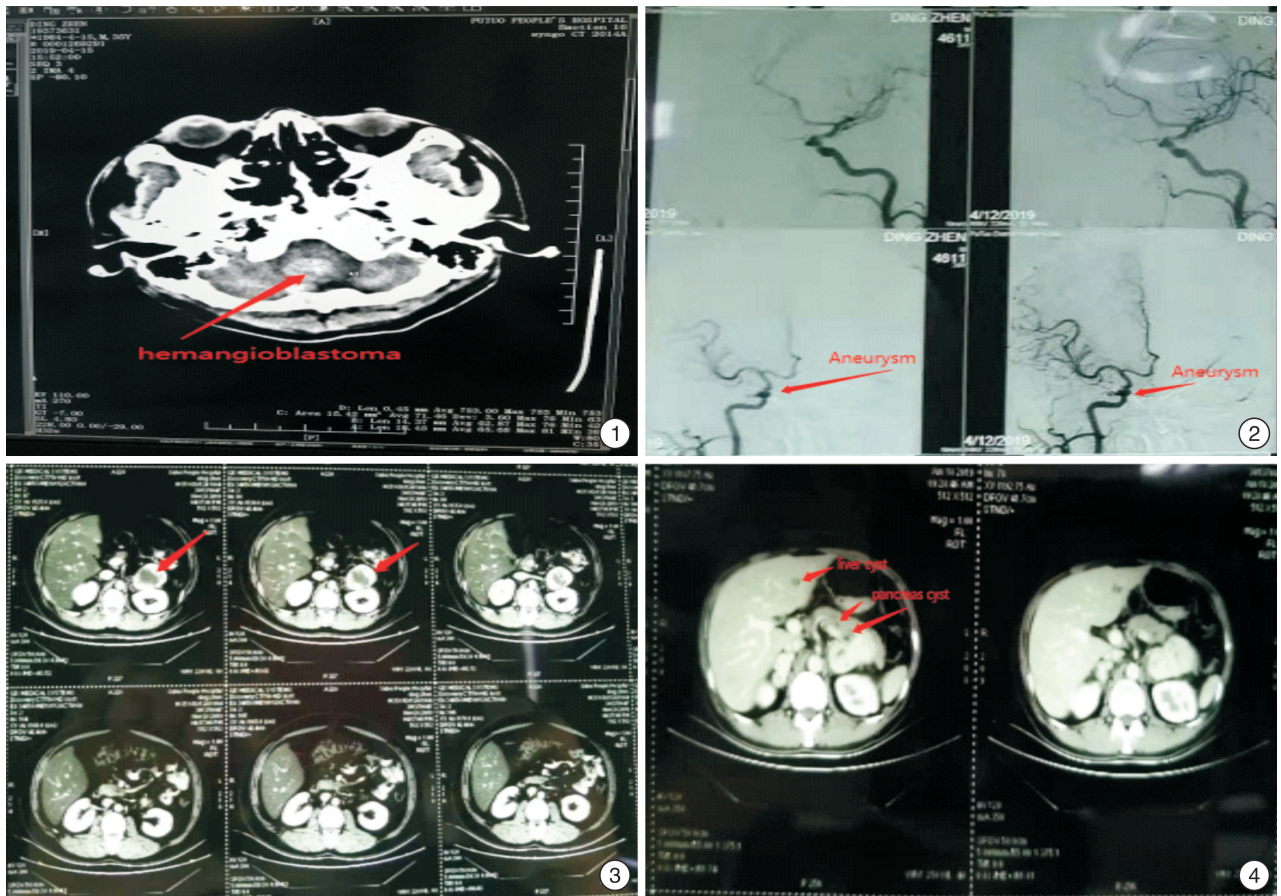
脑部 CT(脑干血管母细胞瘤); 图 2 脑血管造影(左颈内后交通动脉瘤); 图 3 腹部 CT 增强(双侧肾上腺多发占位); 图 4 腹部 CT 增强(肝内多发囊肿;胰腺体尾部小囊肿可能)
